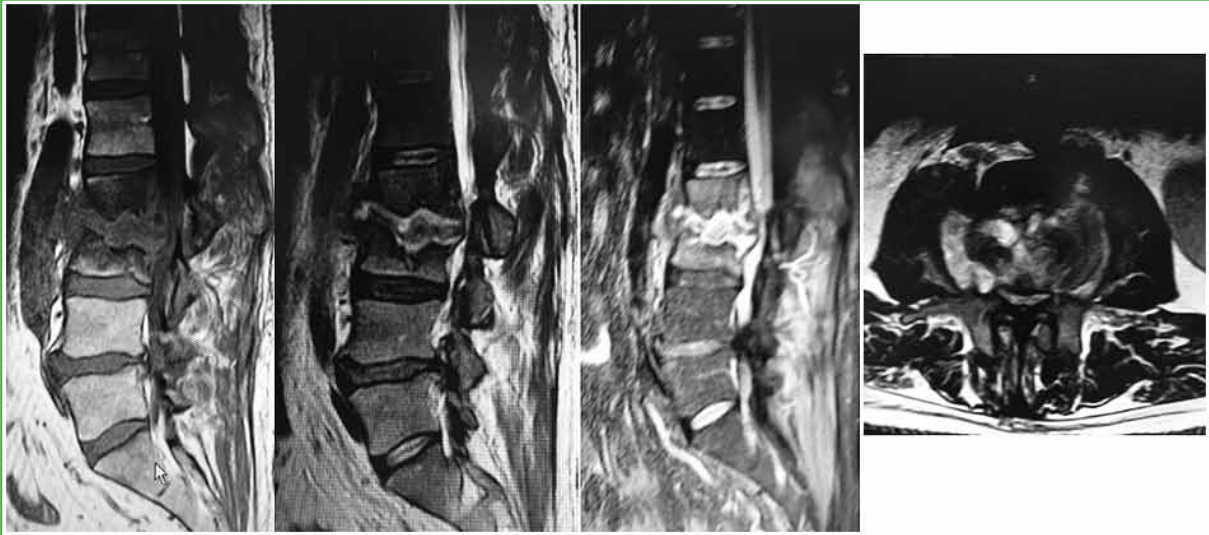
Case 35. MRI, T1- and T2-weighted sagittal sections, T2-weighted with contrast medium, and axial T2-weighted. Defined as L2-L3, A, C2, O2, + (Region: L2-L3, Location: anterior, Involvement: compresses the content, Association: disc and bone infection, Perivertebral: lateral/psoas).
